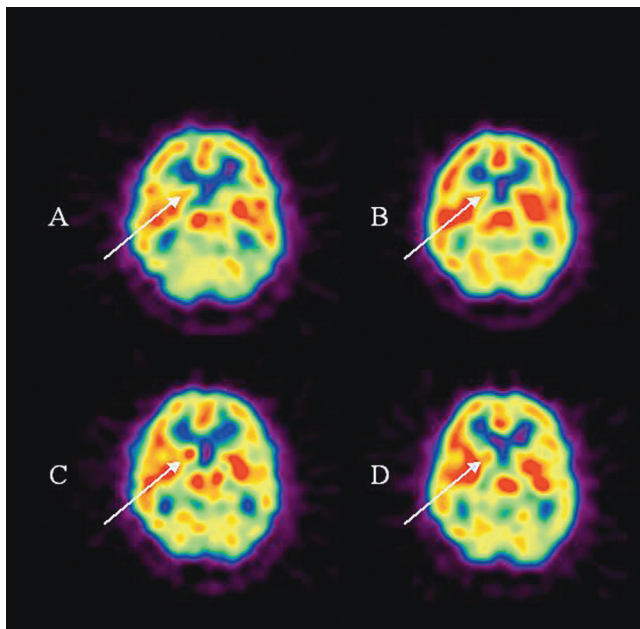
Single-photon emission computed tomography of M technique and right caudate. This figure shows transaxial slices of the brain to show the right caudate. The figure compares the pre and post 1st M technique with pre and post 10th M technique. A. Pre 1st M. B. Post 1st M. C. Pre 10th M. D. Post 10th M. Cerebral blood flow is shown as red > yellow > green > blue. There is a 40% activation increase plus directional blood flow change in the right caudate (indicated with the arrows).
